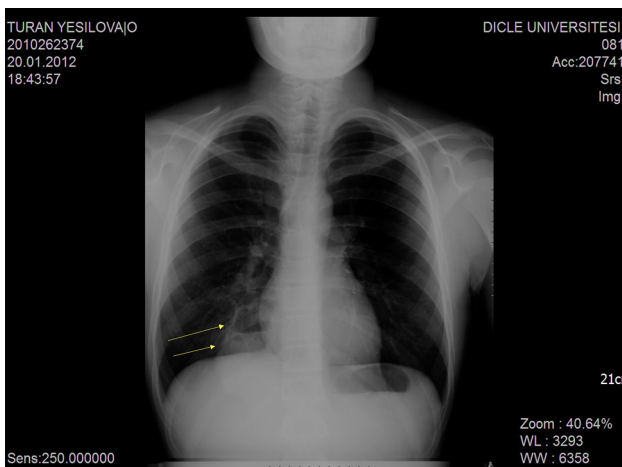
Posteroanterior lung radiography. Opacity is observed in the right paracardiac region with an air-fluid level. Although the lesion seemed to involve the liver on lung radiographic images, no lesion is observed on the liver CT.
